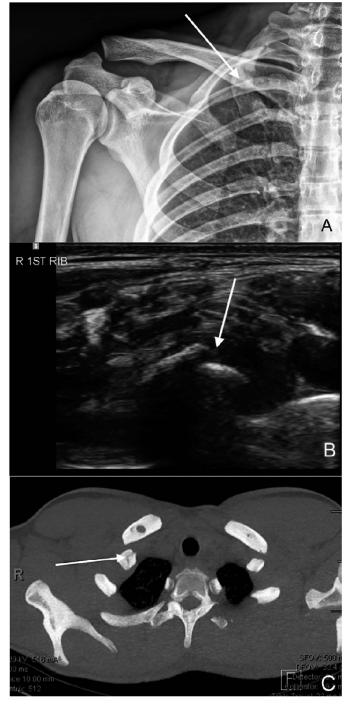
Isolated stress fracture of the right first rib in a 19-yearold male water polo player. A, Shoulder radiograph shows a subtle linear lucency at the lateral aspect of the right first rib (arrow), initially misread as normal. B, Point-of-care ultrasound performed 2 weeks later demonstrates cortical irregularity of the right first rib (arrow). C, Axial chest computed tomography without contrast performed after the ultrasound confirms the nondisplaced right first rib fracture (arrow).
